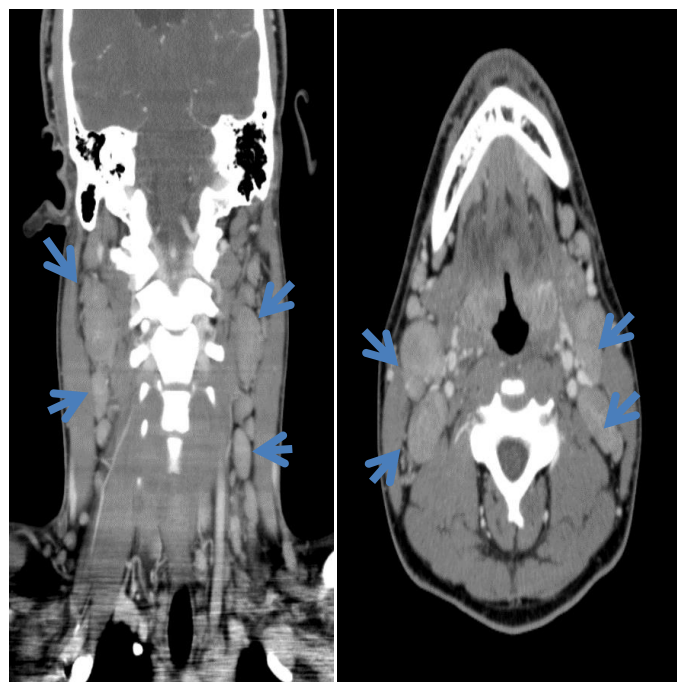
and 2b) CT scan with contrast, sagittal and axial images show associated diffuse cervical lymphadenopathy involving the bilateral cervical (blue arrows).
